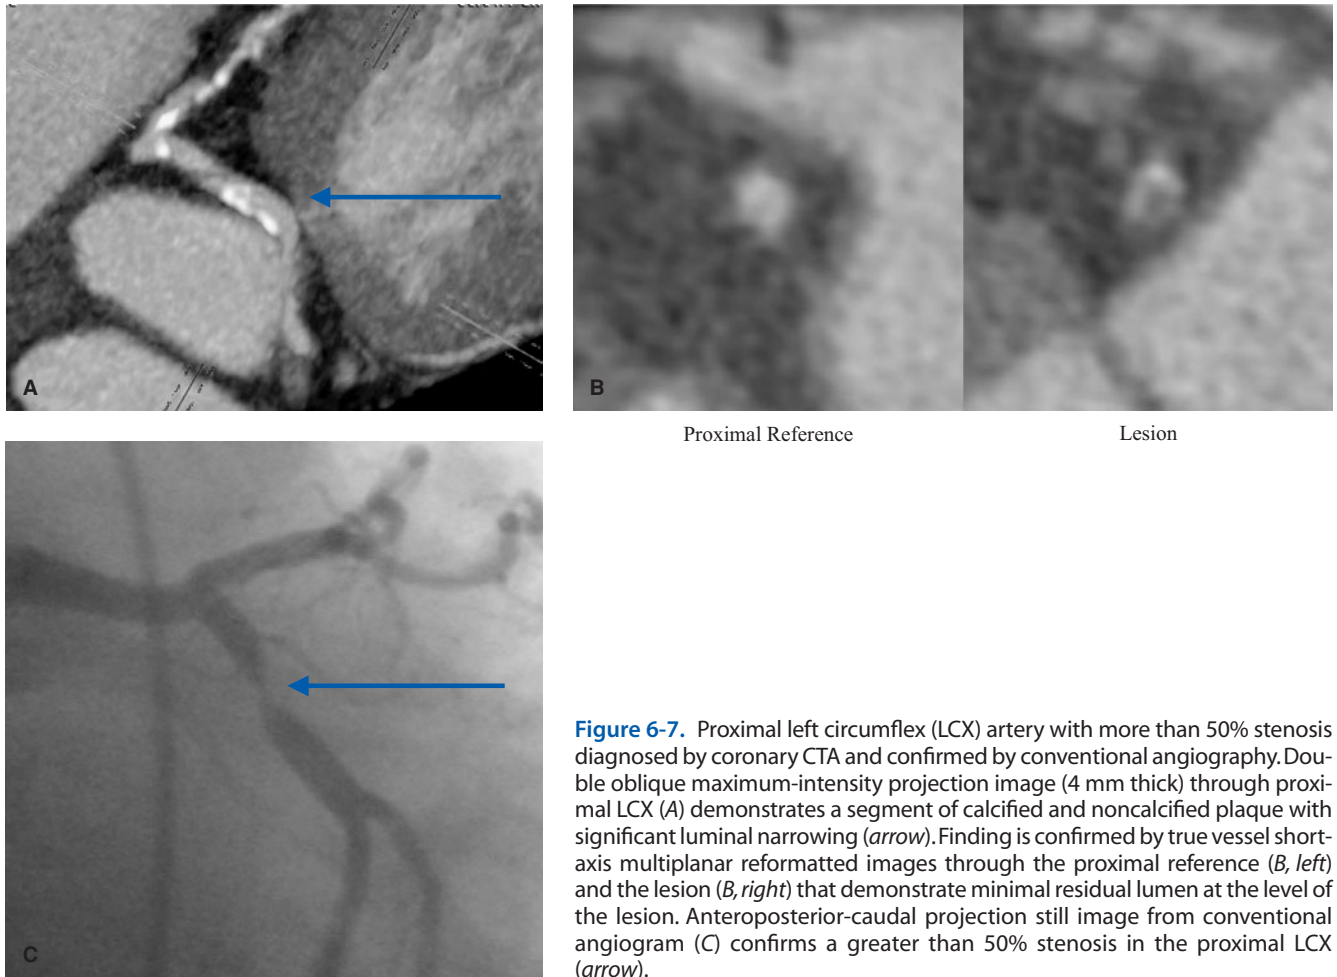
Proximal left circumflex (LCX) artery with more than 50% stenosis diagnosed by coronary CTA and confirmed by conventional angiography. Double oblique maximum-intensity projection image (4 mm thick) through proximal LCX (A) demonstrates a segment of calcified and noncalcified plaque with significant luminal narrowing (arrow). Finding is confirmed by true vessel short-axis multiplanar reformatted images through the proximal reference (B, left) and the lesion (B, right) that demonstrate minimal residual lumen at the level of the lesion. Anteroposterior-caudal projection still image from conventional angiogram (C) confirms a greater than 50% stenosis in the proximal LCX (arrow).
